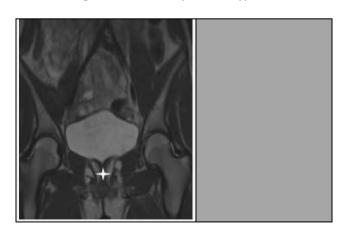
MRI Abdomen and Pelvis: T2WI: (a) Hypoplastic / Infantile and Bicornuate Uterus (White Asterix), (b) Scoliotic Spine Deformity (Yellow Arrow); (c) Butterfly Vertebra (Yellow Arrow)
